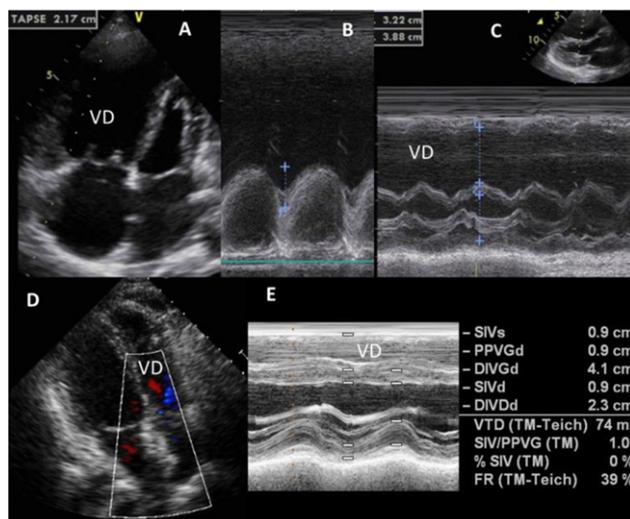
Echocardiography before (A,B,C) and after (D,E) DLT and ASD closure.
